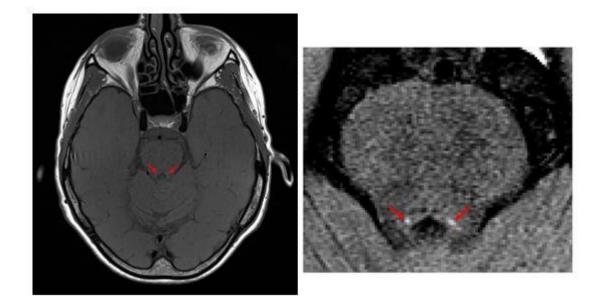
NM-MR image of the LC denoted as two hyperintense areas (red arrows). The axial slice depicted here is level 3 of the 4 consecutive slices measured.
